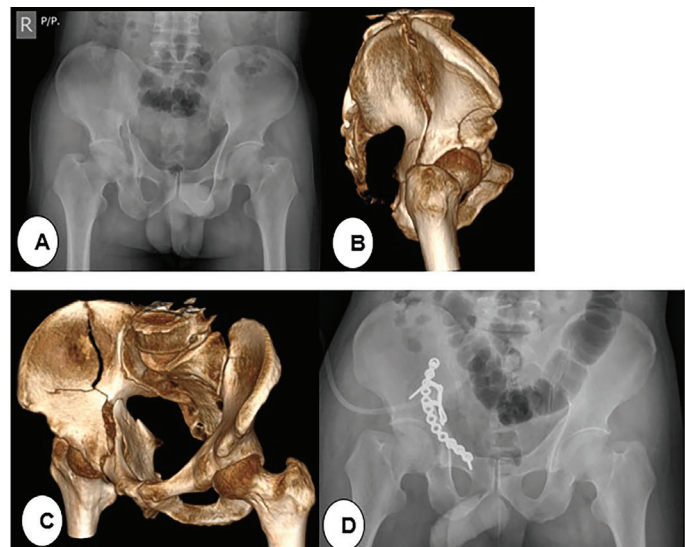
Acetabular fracture after falling from a height was present in a 53-year-old male patient. The patient was operated on the 10th day after trauma with a modified Stoppa approach. Preoperative x-ray and CT sections: A) preoperative direct x-ray, B,C) preoperative axial CT section, D) X-ray on postoperative day 1. The postoperative reduction was assessed as an anatomical reduction.
